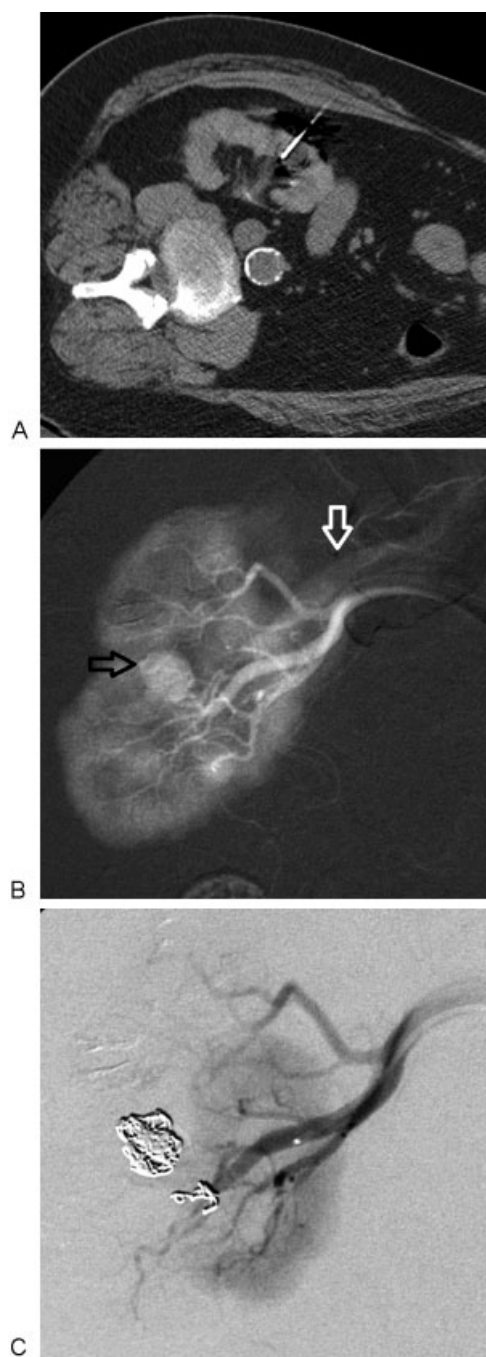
Renal arterial pseudoaneurysm and arteriovenous fistula following radiofrequency ablation. (A) CT shows an electrode in a right renal mass in a 70-year-old woman. (B) DSA image of the right kidney shows a pseudoaneurysm in the right renal hilum (black arrow) as well as early filling of the right renal vein (white arrow). (C) DSA image showing control of the vascular injury postembolization. CT, computed tomography; DSA, digital subtraction angiographic.
